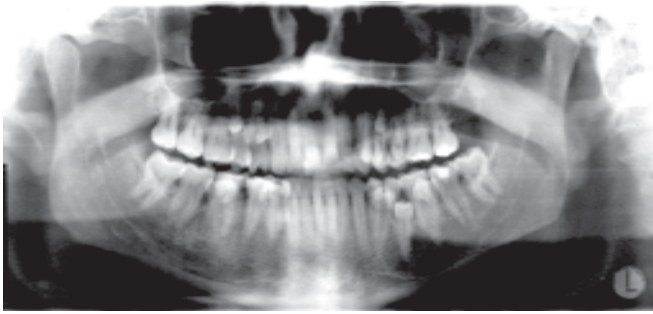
A panoramic radiograph of 34 year male patient shows non-syndrome multiple impacted supernumerary teeth of both upper and lower jaws in the premolar area of four quadrants without any complication to the adjacent teeth.
